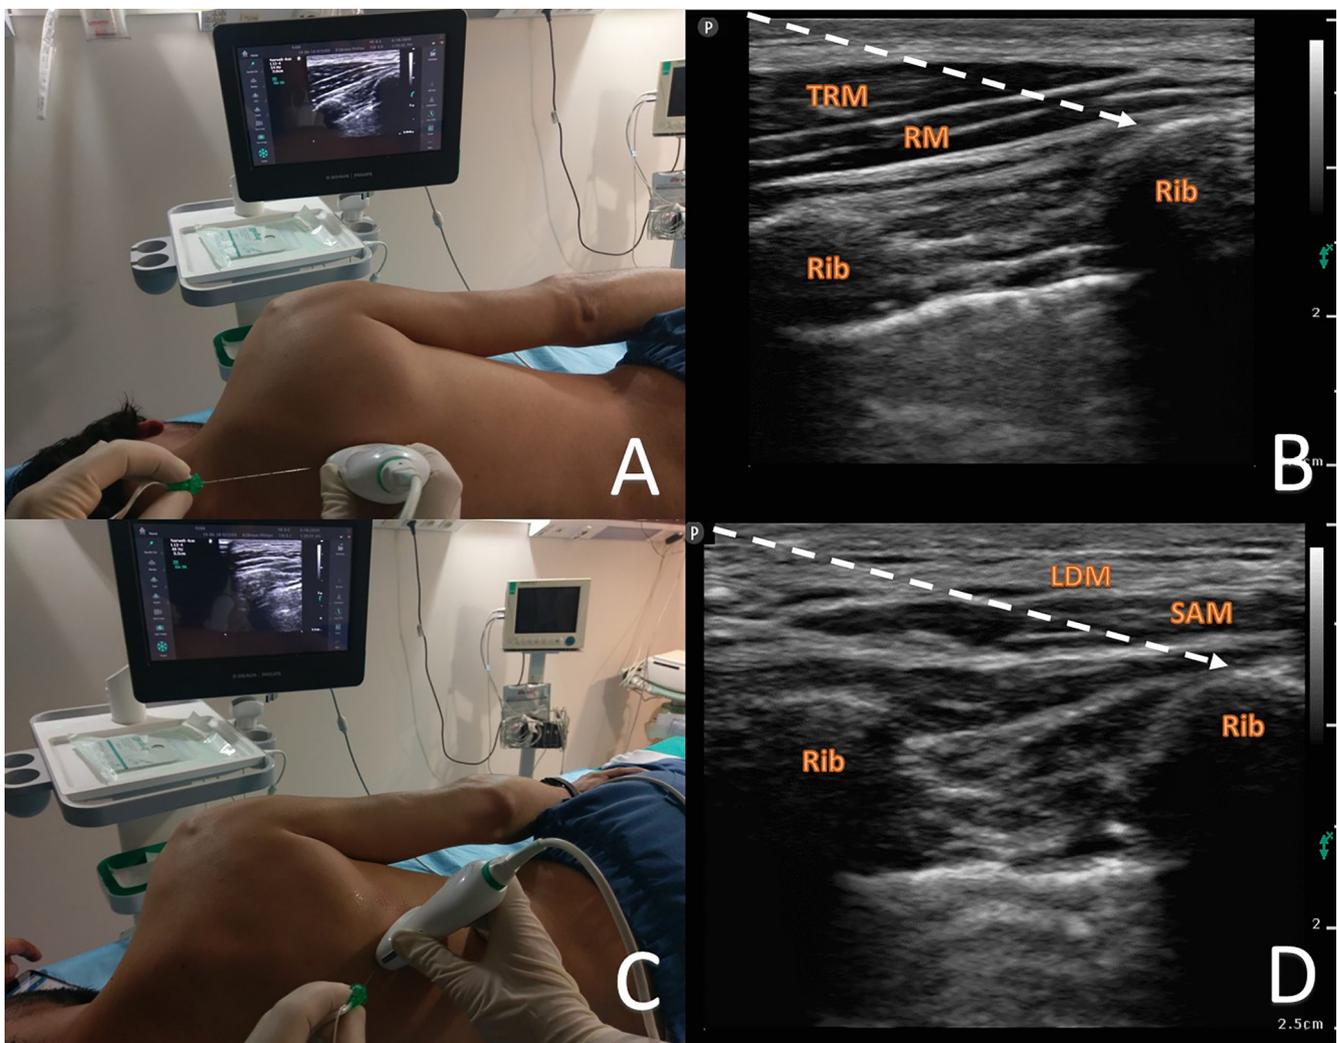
A, B. Ultrasound, patient set up and sonographic image for rhomboid intercostal plane block Fig. 1 C, D. Ultrasound, patient set up and sonographic image for sub-serratus block. TRM: Trapezius Muscle, RM: Rhomboid Muscle, LDM: Latissimus Dorsi Muscle, SAM: Serratus Anterior Muscle.
